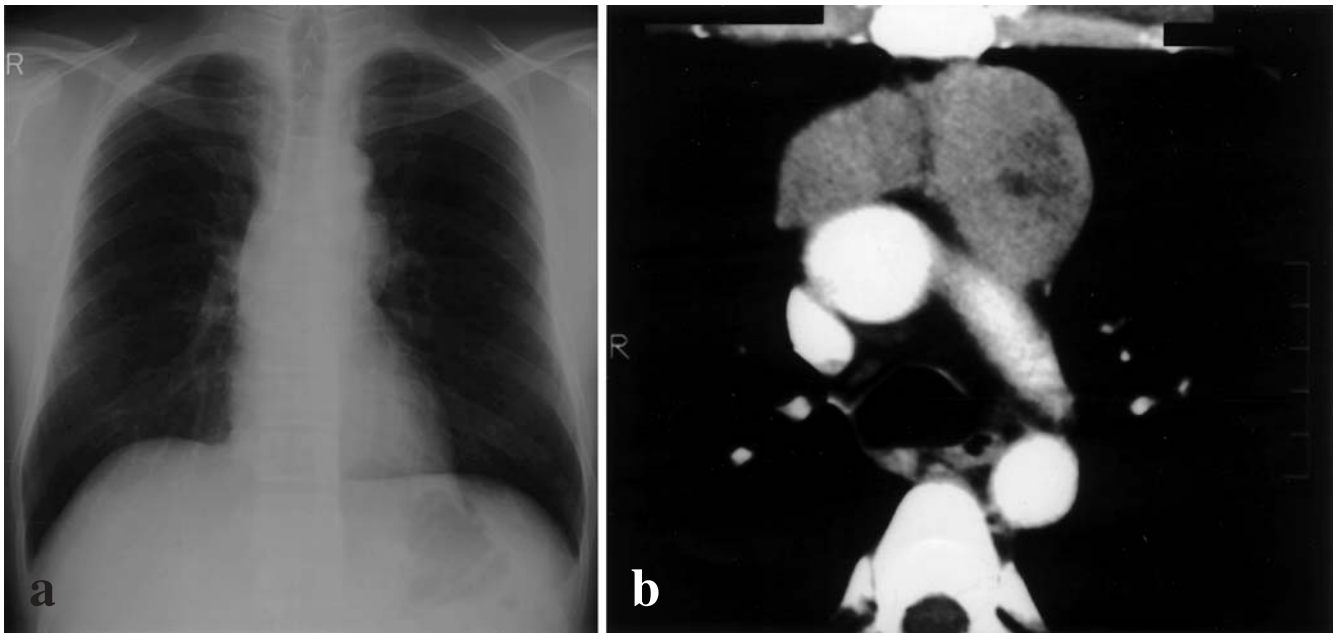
a Chest X-ray film showed a tumor shadow in the left hilum. b Computed tomography scan showed anterior mediastinal tumors, which were separated and enhanced heterogeneously
